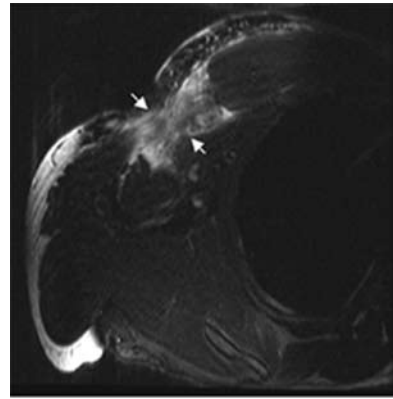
The MRI axial T2 FS showed demonstrate swelling, and abnormal high signal (arrows) at the musculotendinous junction representing high grade partial tear of the pectoralis major muscle. MRI - magnetic resonance imaging.
